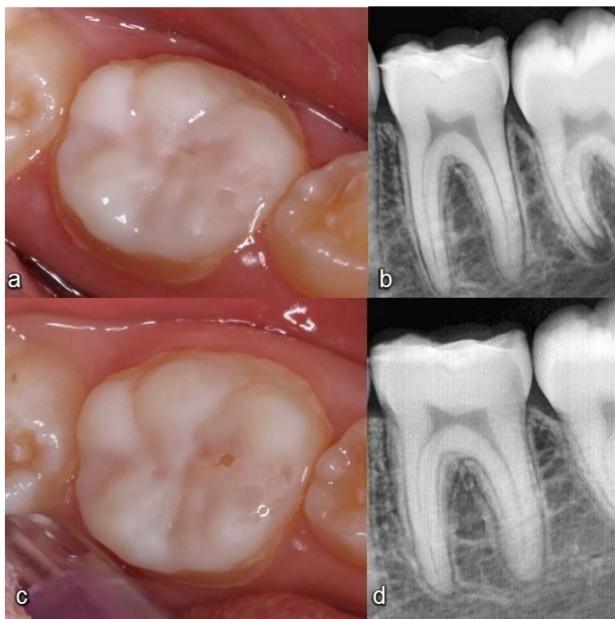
Clinical and radiographic follow-up of Case 1. (a) Intact and functional crown at 12 months; (b) Periapical radiograph at 12 months; (c) Crown with slight mesial wear at 24 months, without functional impact; (d) Periapical radiograph at 24 months
